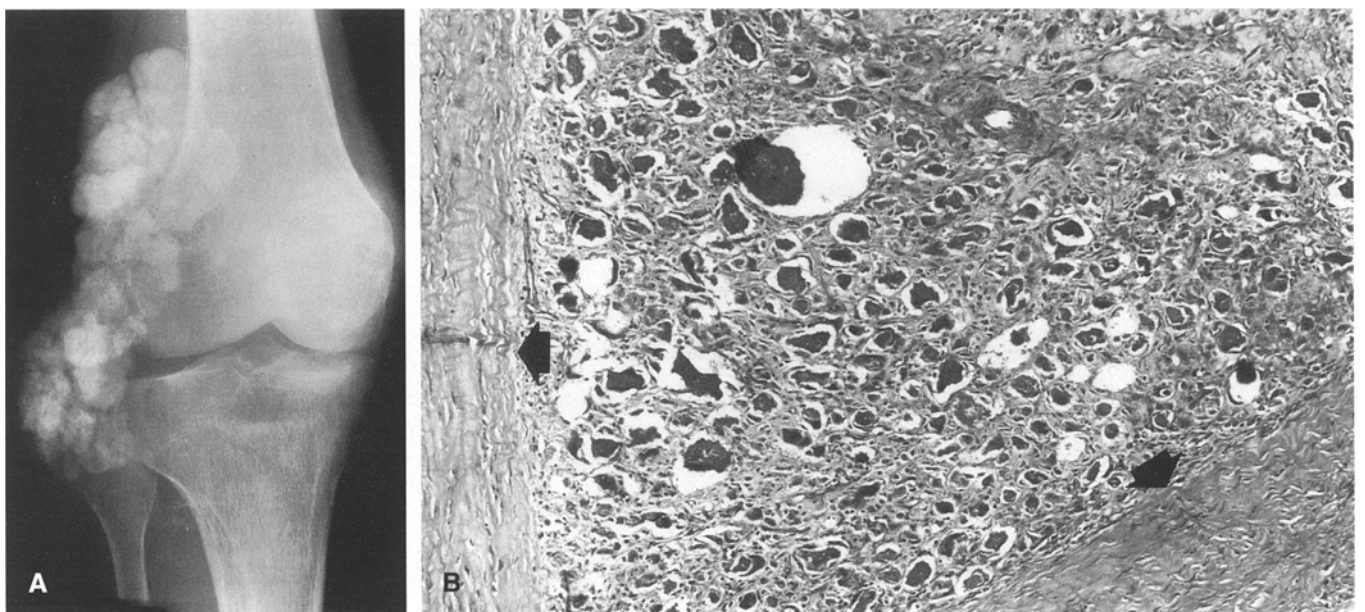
Case 7. A 39-year-old man who was on renal dialysis for 11 years and was hyperphosphatemic noted a mass in his right knee. A The anteroposterior (AP) radiograph reveals homogeneous densely calcified masses separated by low-density septae
